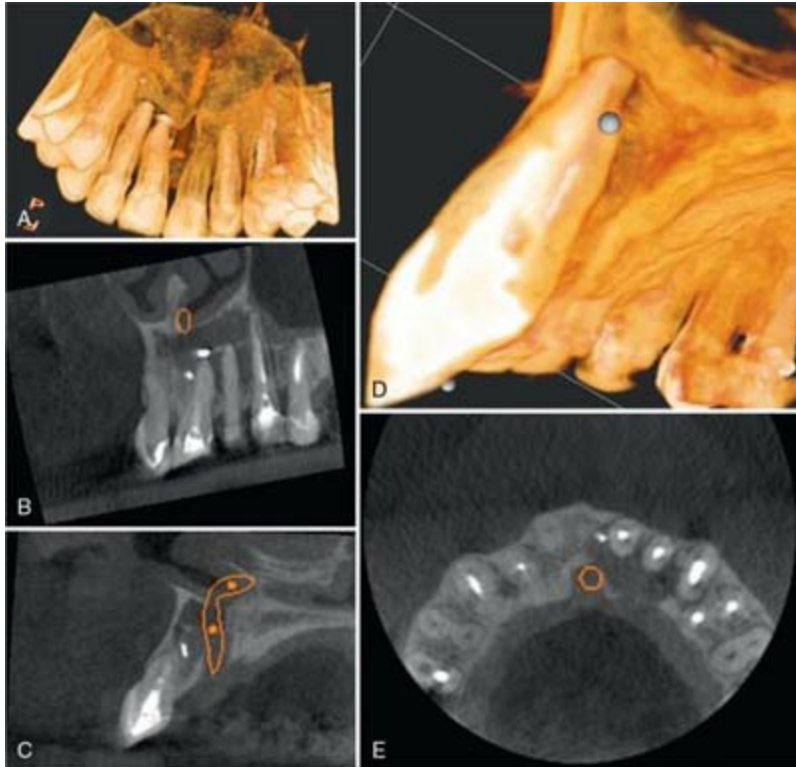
(Case 3, continued): A, Palatal view CBCT reconstruction showing the exit of the nasopalatine neurovascular bundle from the incisive canal. B, Sagittal view demonstrating the periapical radiolucency involving teeth #9, 10, and 11. C, Coronal view the exit of the nasopalatine bundle from incisive canal. D, A 3D reconstruction demonstrating the periapical lesion extension to tooth #11. E, Axial view demonstrating the extension of the lesion, palatal plate perforation, and relation of the nasopalatine bundle to the periapical lesion.
